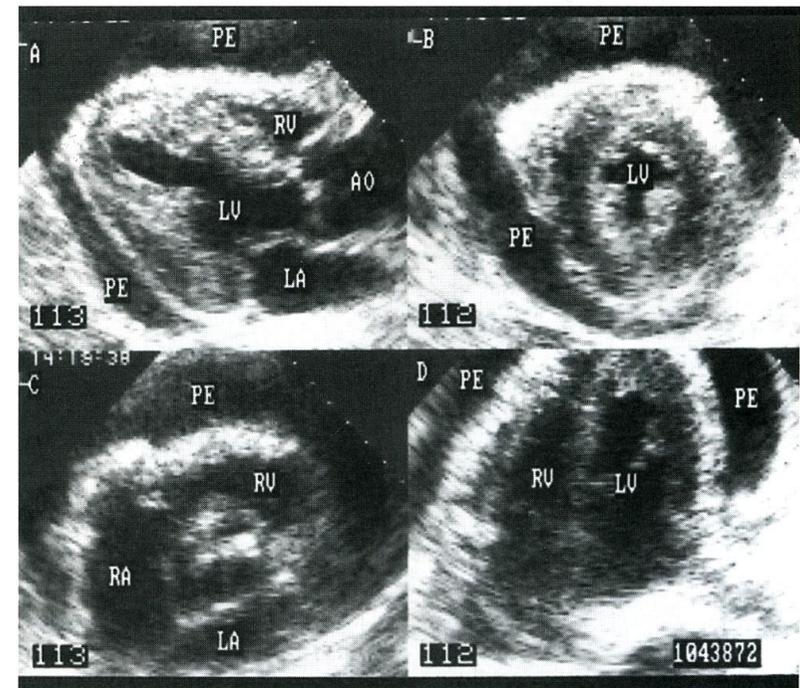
Long-axis (A), short- axis at the papillary muscle (B), short- axis at the base of the heart (C), and apical four-chamber (D) 2-D echocardiograms of a patient with a large pericardial effusion (PE). The relatively echo-free fluid can be seen surrounding the heart in all views. The visceral pericardium is echogenic and probably thickened. RV = right ventricle; LV = left ventricle; AO = aorta; LA = left atrium; RA = right atrium.
